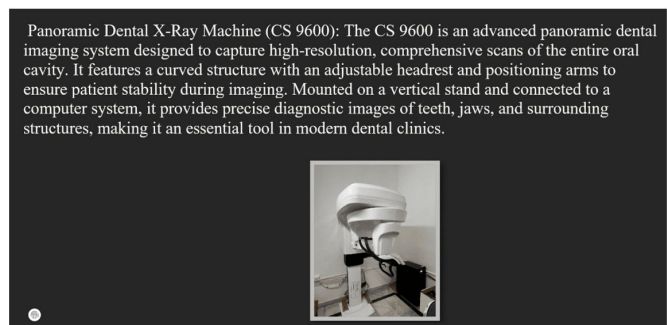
Dental X-Ray Machine (CS9600)
